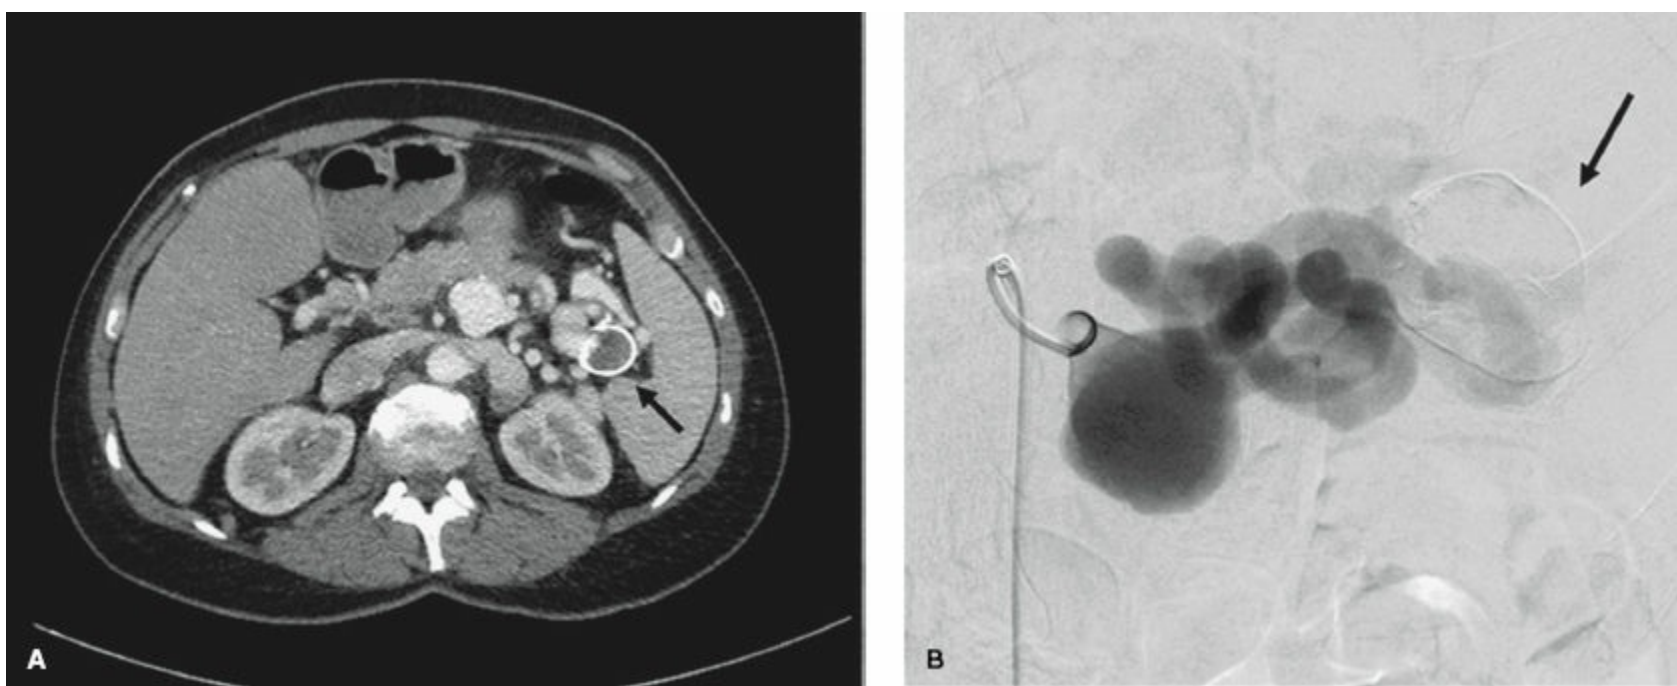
(A) CT angiogram and (B) splenic arteriogram revealing a tortuous splenic artery with two large aneurysms affecting the main splenic artery; the distal aneurysm (arrow) has extensive calcification and mural thrombus.
